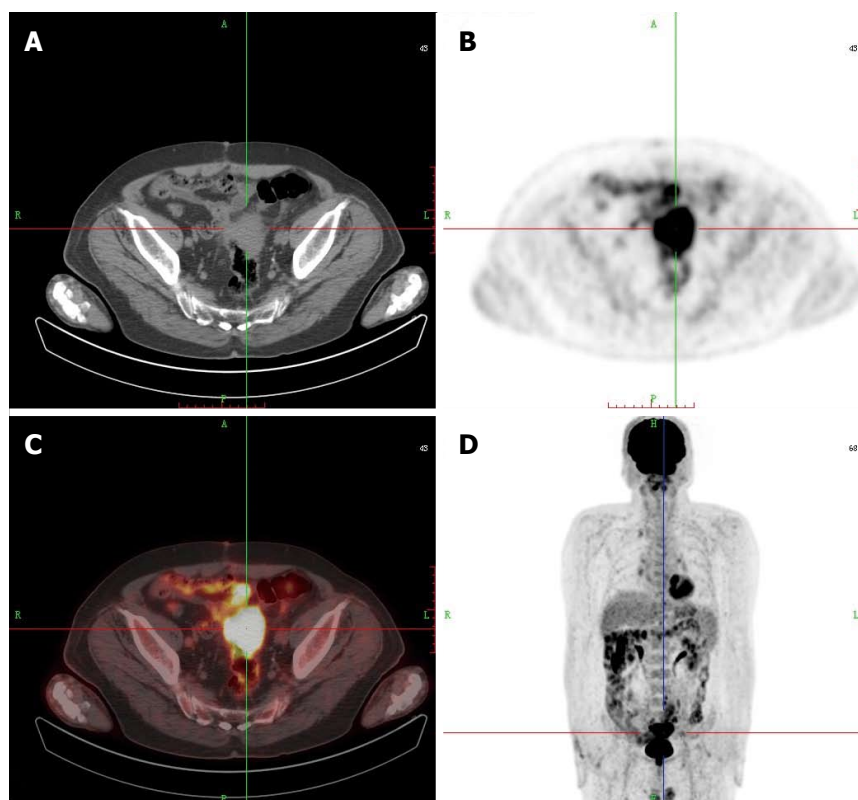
Positron emission tomography/computed tomography findings before treatment. Positron emission tomography/computed tomography showed ^{18}F -fluorodeoxyglucose hypermetabolism at the colorectal anastomotic site and paracolic lymph nodes. The SUV_{max} was 18.9 at the lesion arising at the anastomosis. The SUV_{max} of paracolic lymph nodes was 6.8.
